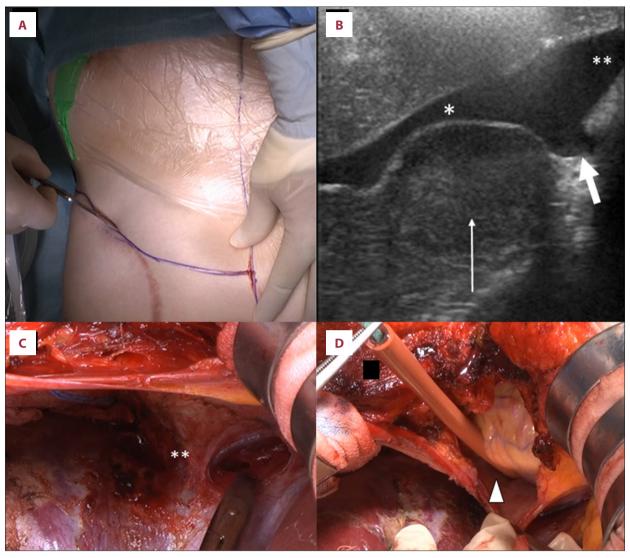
Reoperation for recurrent liver tumor was performed via (A) an upper median plus transverse incision. (B) Intraoperative ultrasonography showed the round mass (thin arrow) as a hypoechoic lesion compressing the right hepatic vein (\*) and the area adjacent to the inferior vena cava (IVC) stump (thick arrow). The middle hepatic vein (\*\*) was not compressed by the tumor. (C) The confluence of the MHV was isolated, but dissection around the RHV and the front of the IVC was difficult due to tumor compression. (D) To control injury to the IVC, the IVC in the pericardium was encircled by a tourniquet (arrowhead) before hepatectomy.
